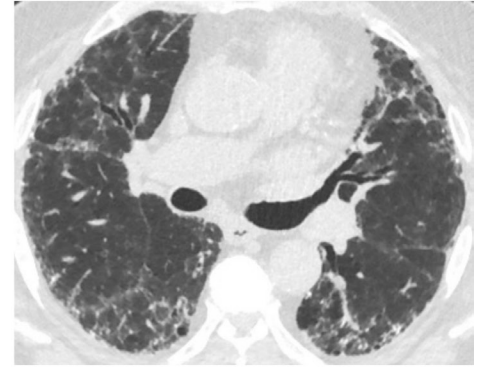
CT axial images that show an increase in high-attenuation areas over time between Examinations 1 (2000–2002) and 6 (2016–2018). (A,B) CT images of one participant with high-attenuation areas per cent of 4.34 at Examination 1 and 12.21 at Examination 6. (C,D) CT images of another participant with high-attenuation areas per cent of 7.38 at Examination 1 and 17.42 at Examination 6.
